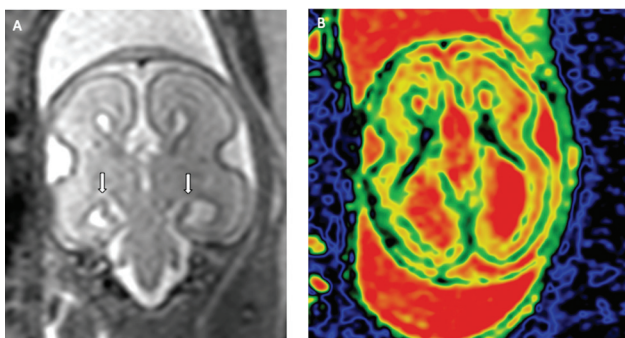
Coronal T2-turbo spin echo (TSE) image of the fetal brain showed altered vertical orientation of the hippocampal cortex on both sides (A, white arrows). Transverse color-coded diffusion-weighted magnetic resonance imaging (MRI) images of the fetal brain showed a 5 layered cerebral mantle with preserved telencephalic lamination (B).
